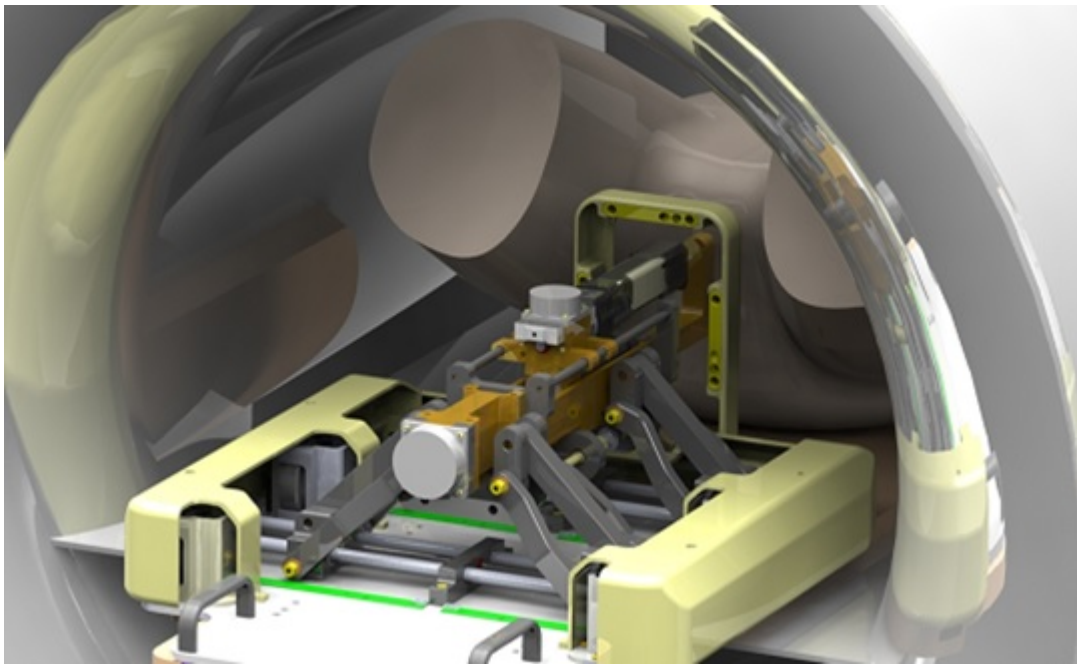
A render of the needle placement robot in position to perform an in-bore MRI-guided targeted prostate biopsy.
